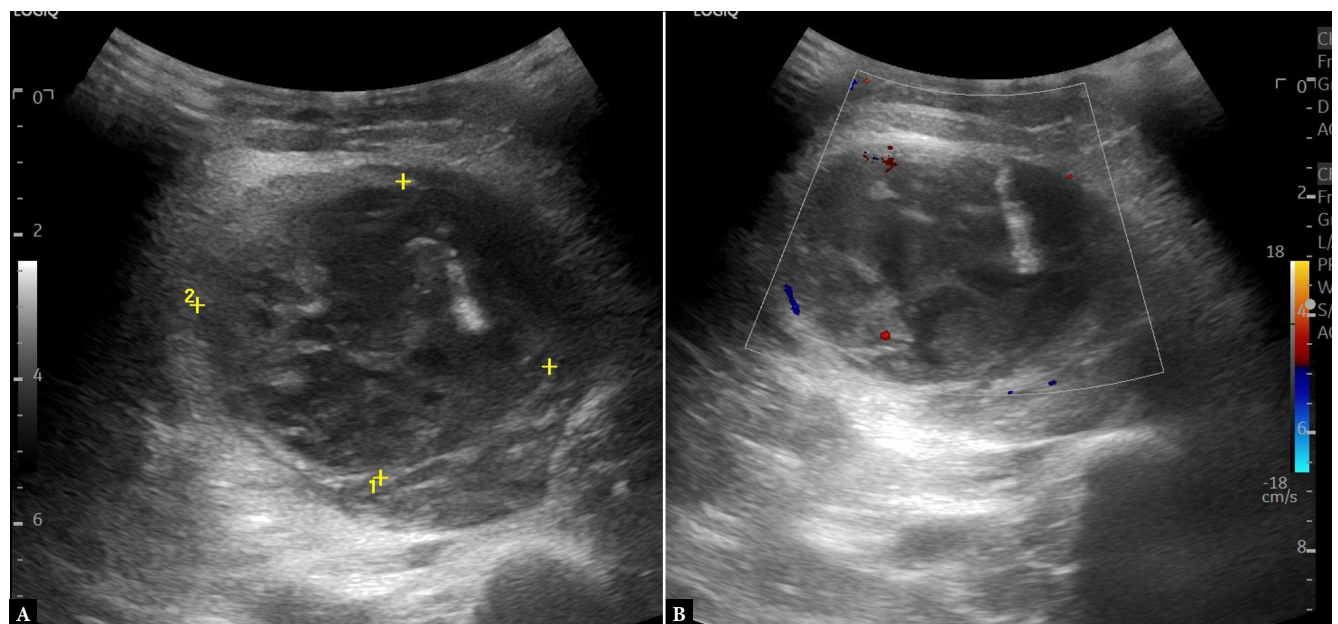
Ultrasound of the right thigh showing a large heterogeneous intramuscular collection within the biceps femoris muscle (4 × 5 × 10 cm), containing mixed hypochoic and anechoic components (A) and presenting no internal vascularity on CD (B), suggestive of an intramuscular abscess
